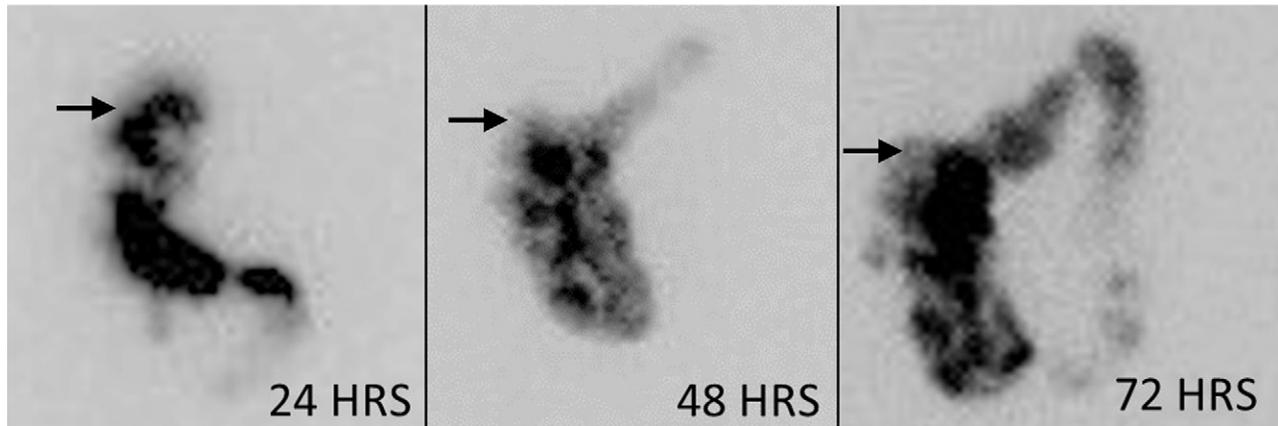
Colonic scintigraphic images show typical findings of colonic inertia. There is predominant right-sided colonic retention with most activity remaining proximal to splenic flexure (arrows). The geometric center is less than 4 at both 48 and 72 hours.
